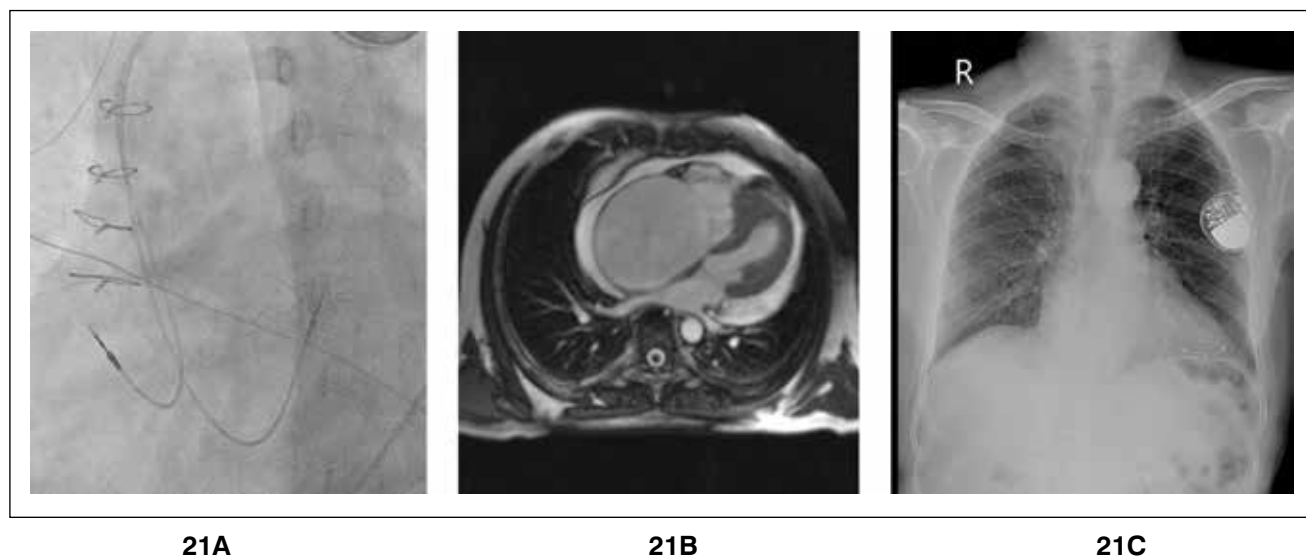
21A- In the case of endomyocardial fibrosis, an active fixation lead is placed in the outflow tract septum. Active fixation lead is required for stability at this location, especially in the presence of TR. 21B- Cardiac magnetic resonance apical 4-chamber image showing endomyocardial fibrosis with dilatation of the right atrium. 21C- Placement of a lead in the coronary sinus for pacing using an LV active fixation lead in a patient with endomyocardial fibrosis.
